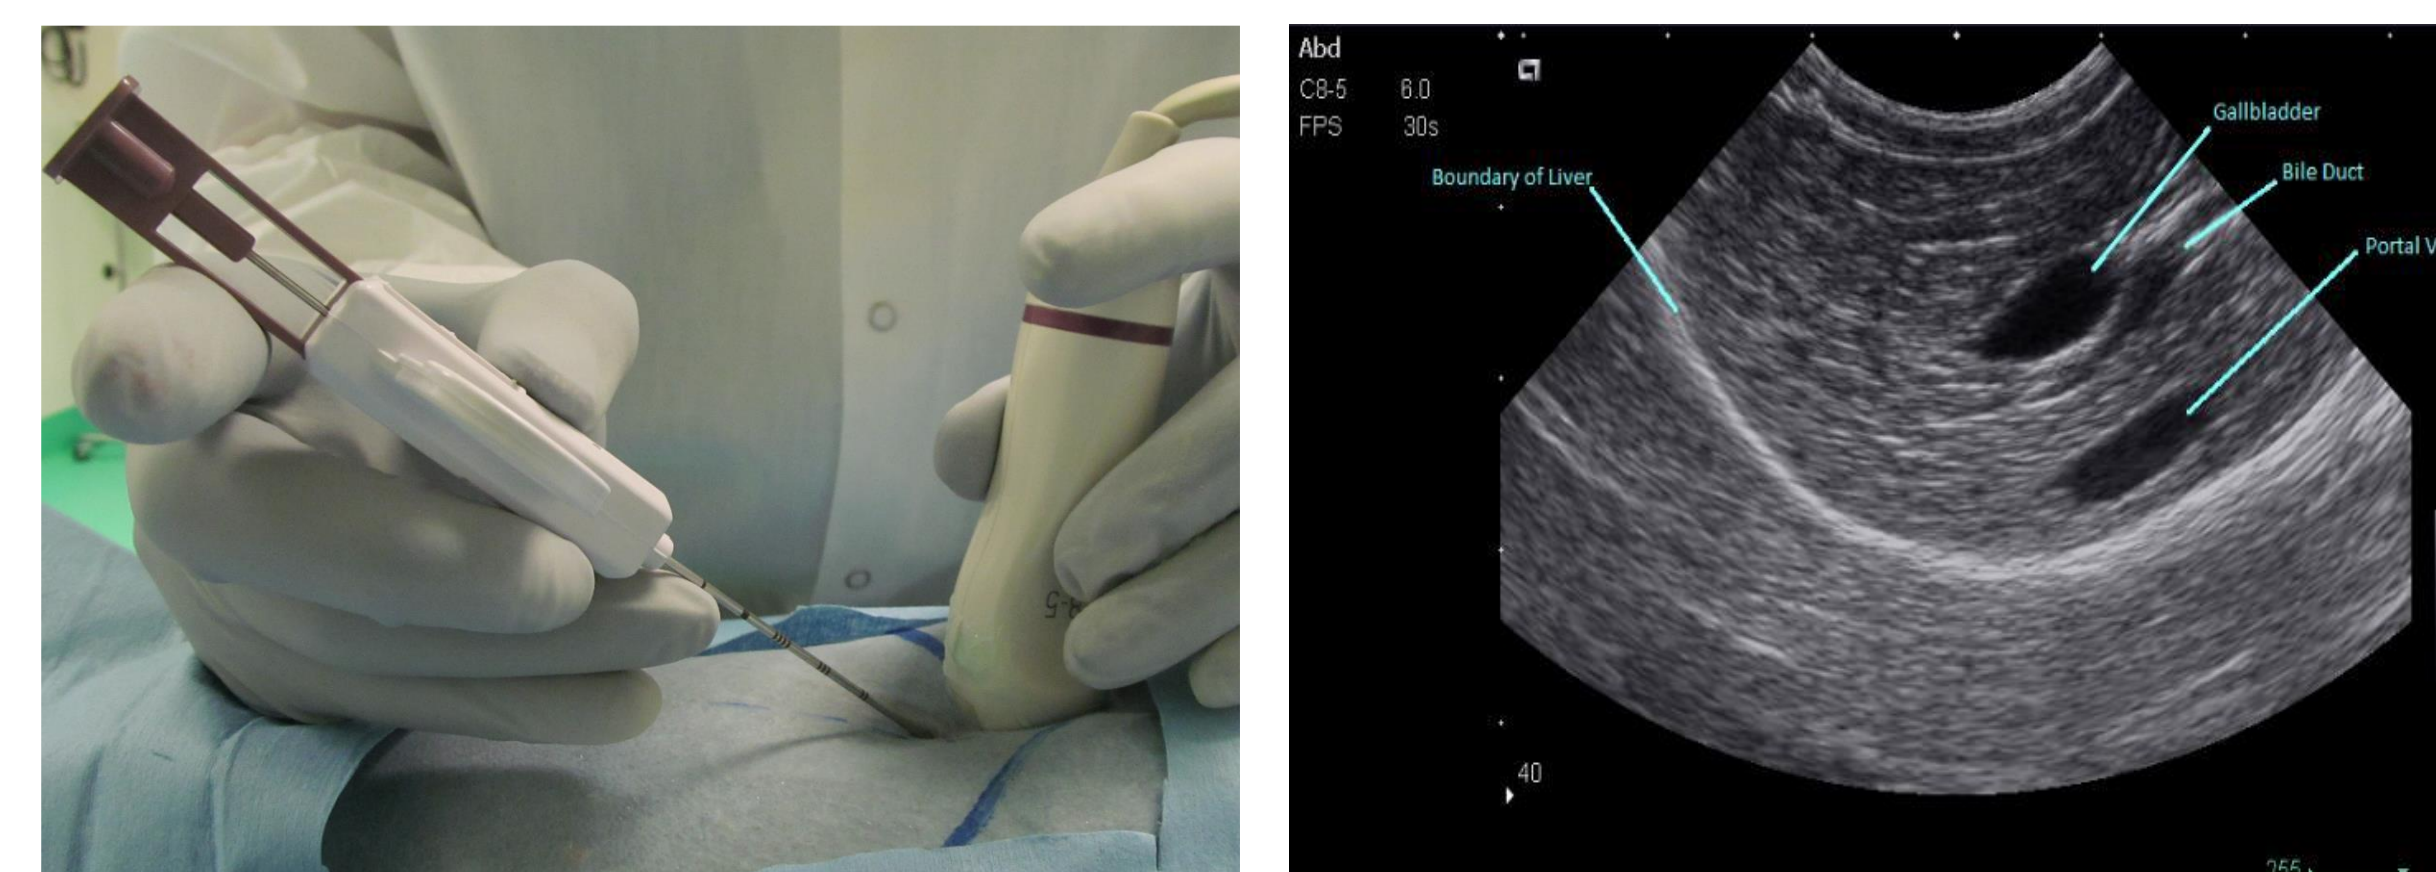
2D ultrasound image of the liver (solid white line), gall bladder, and large vasculature structures (black oval areas)
